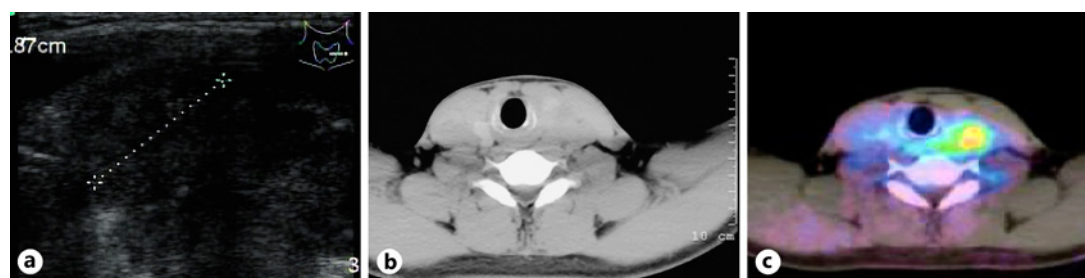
Preoperative imaging. a Cervical ultrasonography shows a low echoic and unclear solid mass in the lower pole of the left thyroid lobe. b CT image reveals a low-density mass in the left thyroid lobe. c Positron-emission tomography shows ^{18}F -FDG accumulation in the left thyroid tumor (standardized uptake value of 5.29).
